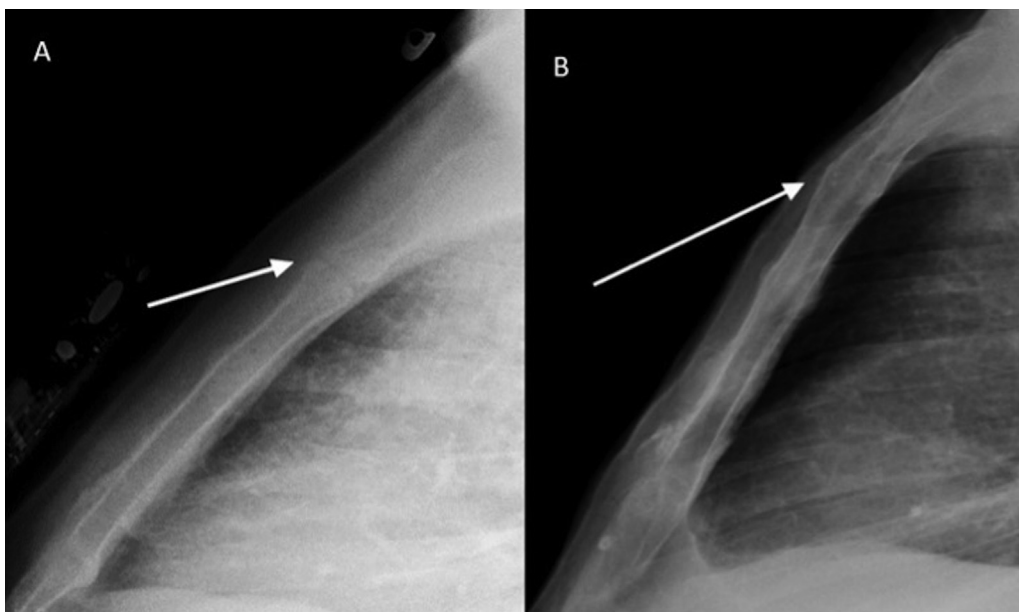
Lateral view of chest radiograph showing (A) unfused and (B) fused manubriosternal joint (white arrow in A and B, respectively), the latter indicating age as more than 62 years.
